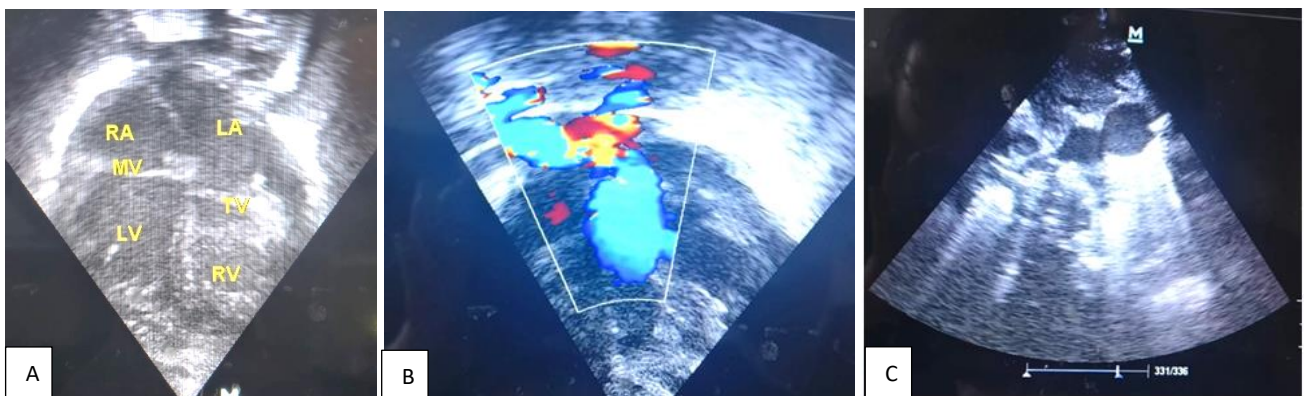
(A-C): Echocardiography showed CCTGA: showing 4 chamber view, with the right AV valve insertion higher than the left AV valve, showing blood from LV flowing to the pulmonary artery, short axis view showing aorta is present to the left and to anterior to the pulmonary artery.
